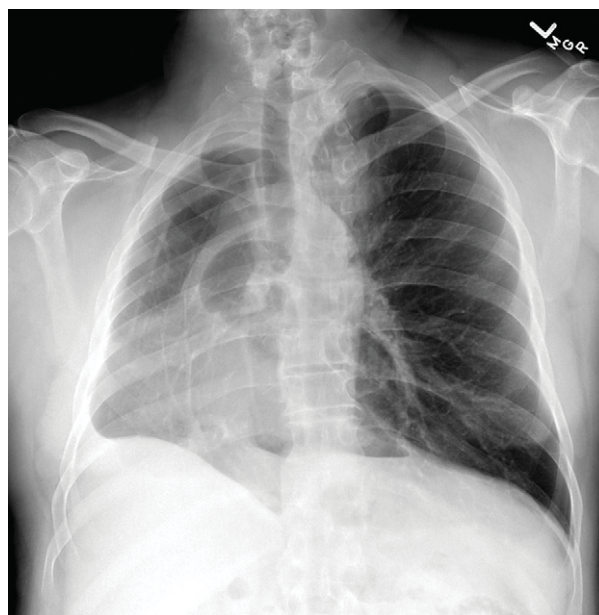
The initial chest radiograph.
